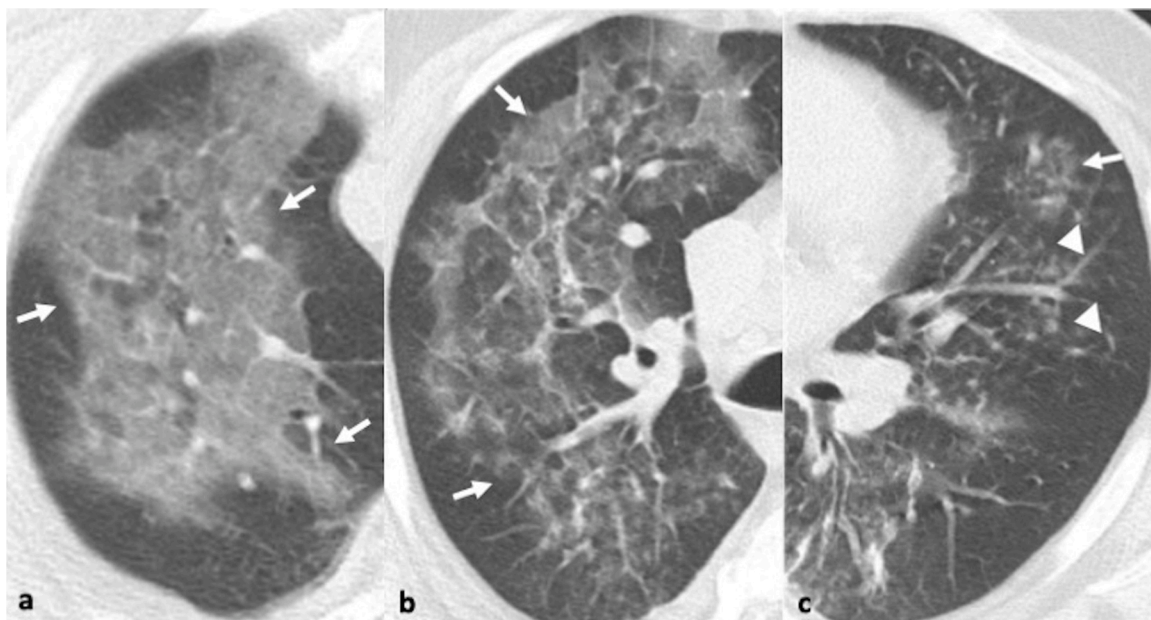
47-year-old male with pneumonia due to human metapneumovirus. 6a-c. Axial CT images in the right apical region and right and left mid zone reveal three coexisting patterns: ground glass opacity (arrows, a-c), reticular changes and ill-defined centrilobular nodules (arrowheads, c).
